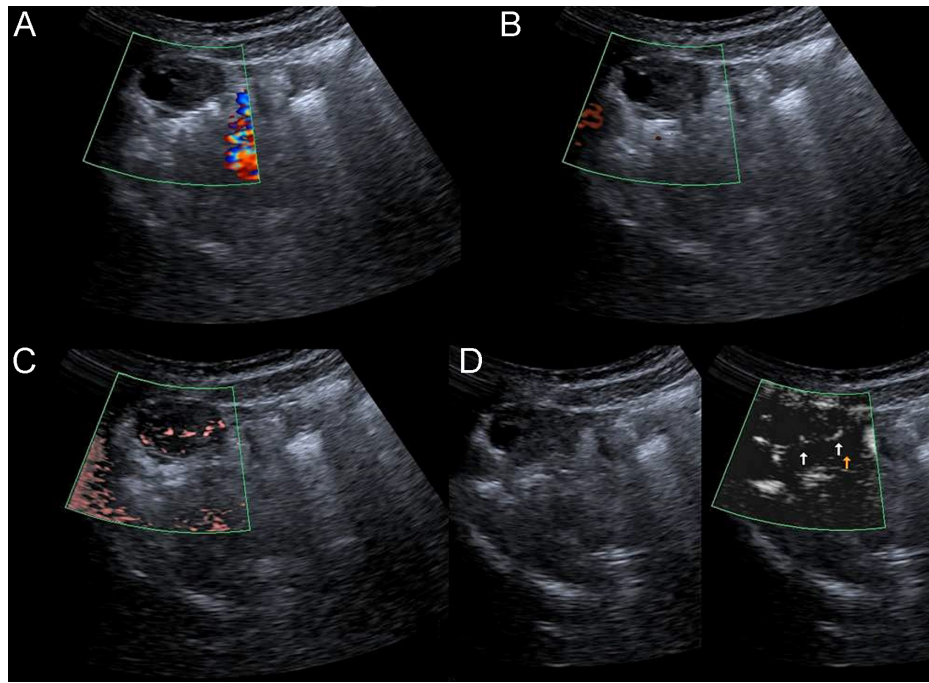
Doppler imaging of a 7-year-old girl with precocious puberty. There is no vascularity with color Doppler imaging (A) and power Doppler imaging (B). Both ovarian vascularity grades were 0. There are 2 linear and several punctate vascularities with cSMI (C) and mSMI (D), graded as 3.
